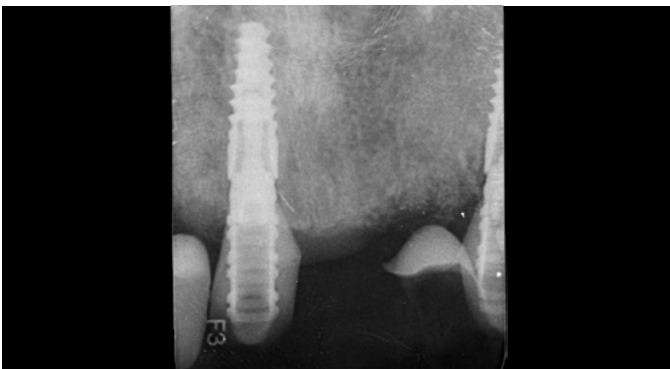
Post-operative radiograph of implant showing implant at the UR1 site
